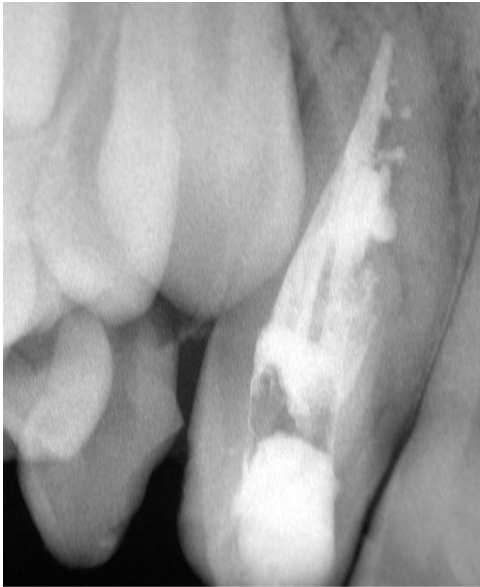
Case 2. Initial radiograph of the first treatment of item 1.2.
